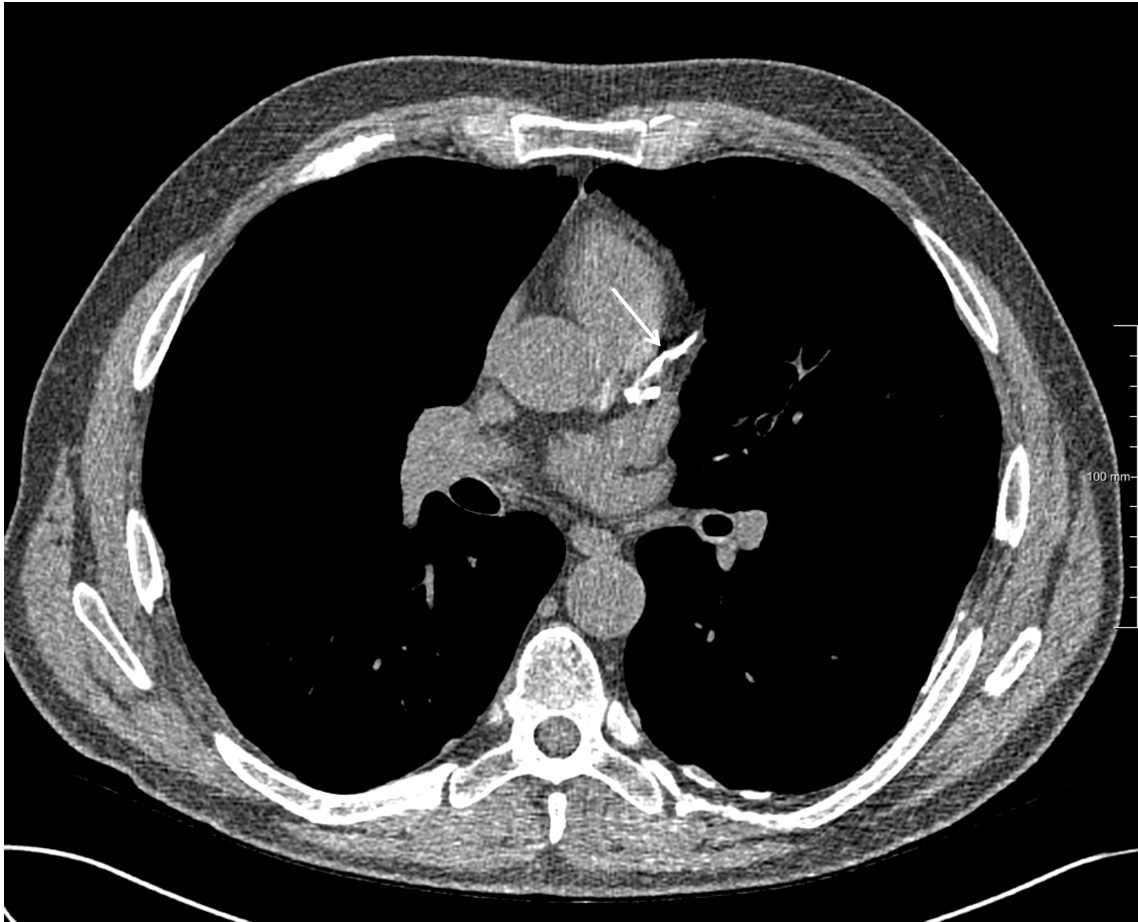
Coronary artery calcification found on CT Scan (arrows)
